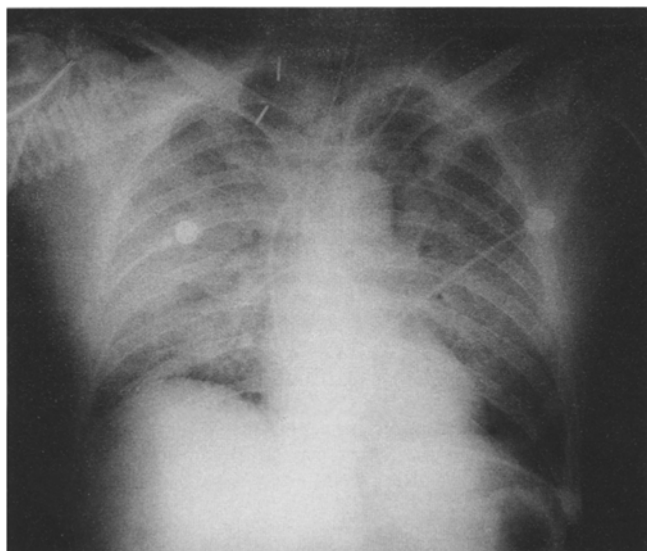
Chest radiograph of a 53-year-old man on day 1 after ethylene glycol butyl ether poisoning
